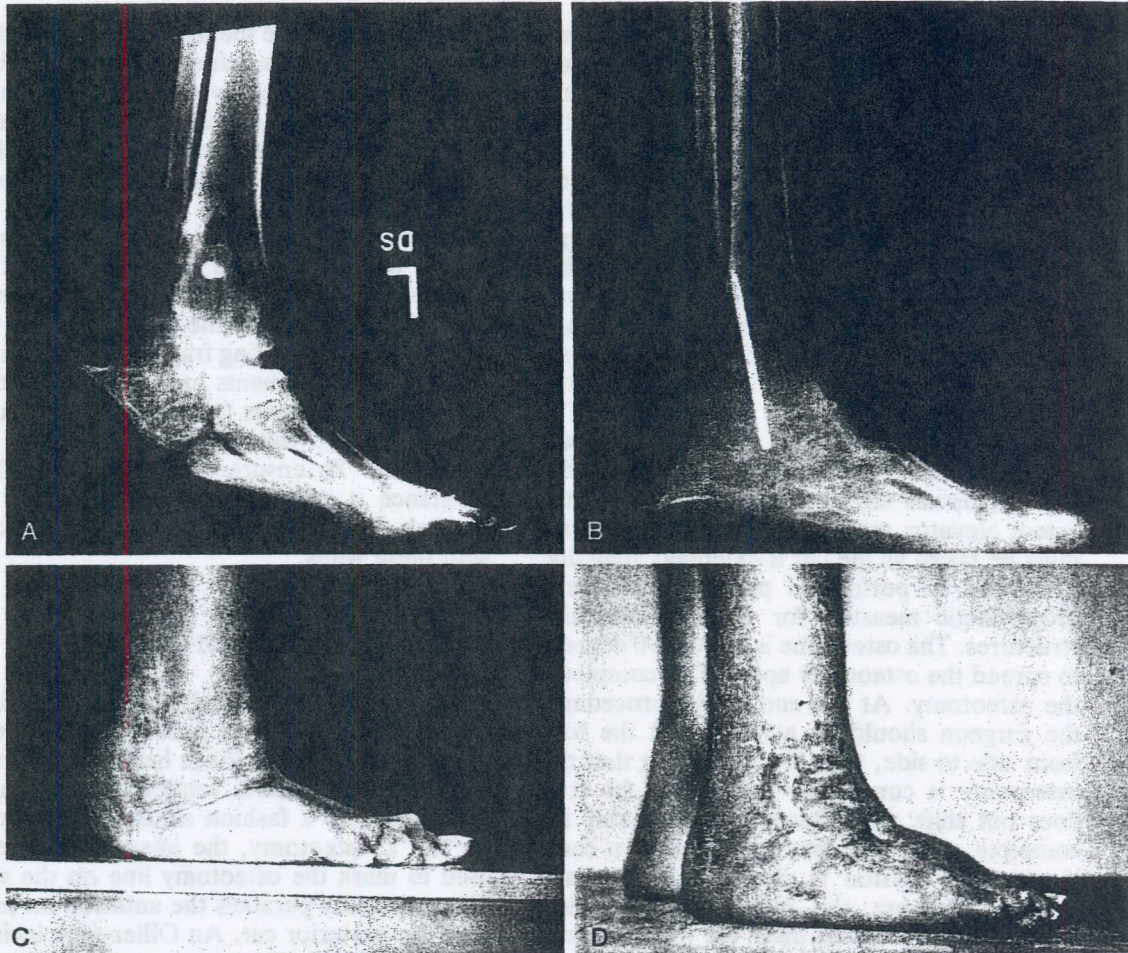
(A), Severe shortening of the foot following talectomy for a clubfoot deformity. Note the equinus deformity of the heel and the painful nonunion of the tibia and navicular. (B), The foot was osteotomized across the calcaneus and metatarsals. The nonunion was débrided and compressed. The final radiograph after correction of the foot deformity demonstrates the plantigrade foot with re-establishment of the heel and a longer forefoot. (C and D), The appearance of the foot before and after the correction of deformity. This patient also had a simultaneous leg lengthening and widening procedure. (Courtesy of Dror Paley, M.D.)
